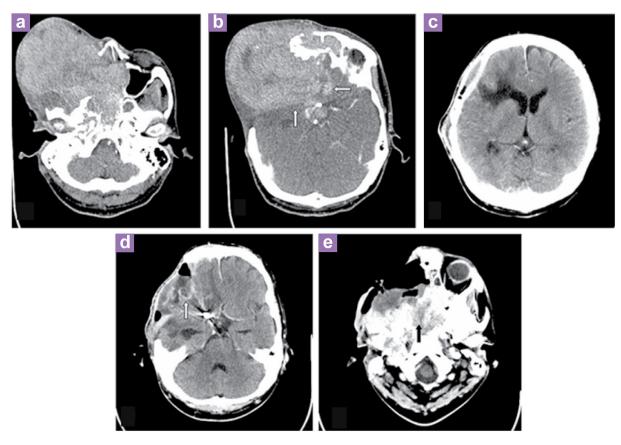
Contrast-enhanced CT at the third admission: The Mass increased in size, crossed the midline and involves the entire frontal, ethmoid and sphenoid sinuses as well as the entire clivus and cavernous sinuses (3a, 3b); it has extended into the bifrontal and right temporal lobes with no clear plane with the brain parenchyma (3b-arrows). Contrast-enhanced CT after third surgery: Hypodensity with fluid density at the right frontal lobe associated with volume loss secondary to tumour removal (3c). Subdural fluid collection at the operative site with peripheral enhancement probably secondary to wound infection (3d-arrow). The soft-tissue lesion is still seen within the remaining ethmoid-sphenoid sinuses, clivus and infratemporal fossa consistent with a residual tumour (3e-black arrow).
